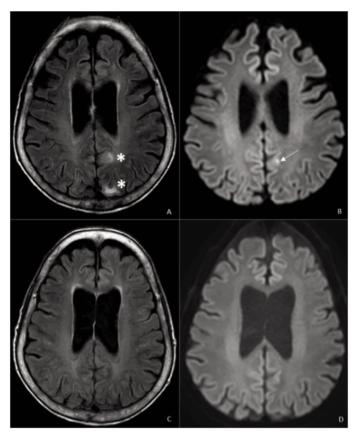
Brain MRI. Initial (A and B) and one month follow up (C and D) brain MRI. Hyperintense small parieto-occipital lesions (*) in T2 Flair (A), one with restricted diffusion (b1000) (white arrow), with no mass effect (B). The lesions resolved after one month (C and D).
